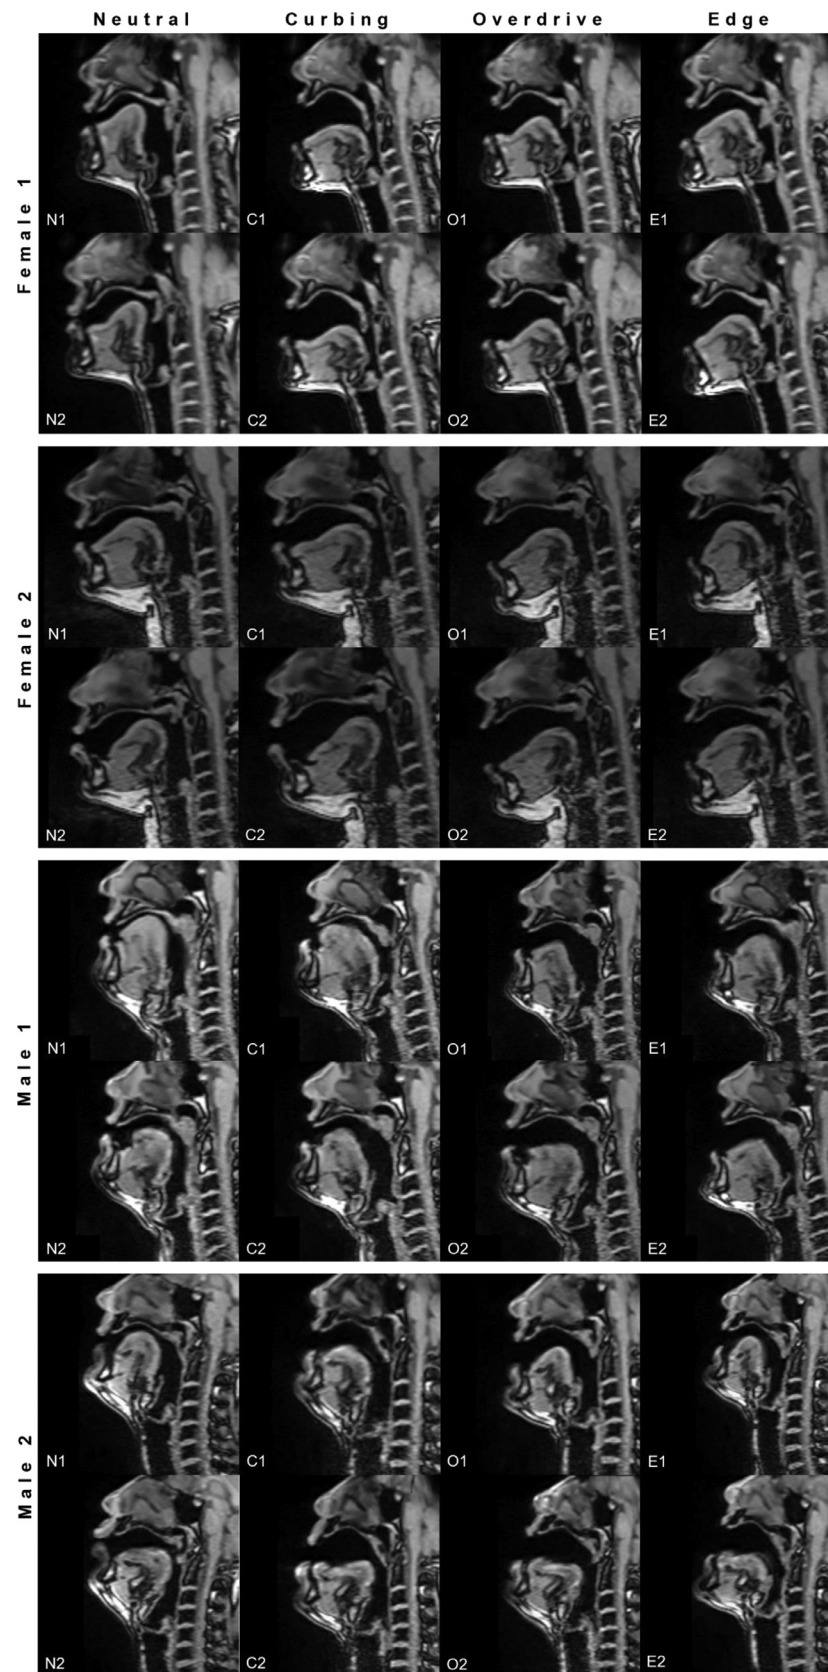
Singer profiles. MRI mid-sagittal projections of vocal mode samples from all singers; Female 1, Female 2, Male 1 and Male 2. Each image has been labelled with first letter of vocal mode name (N, C, O, E) and sample number (1, 2). For vowel descriptions, see [Table 1](#).
